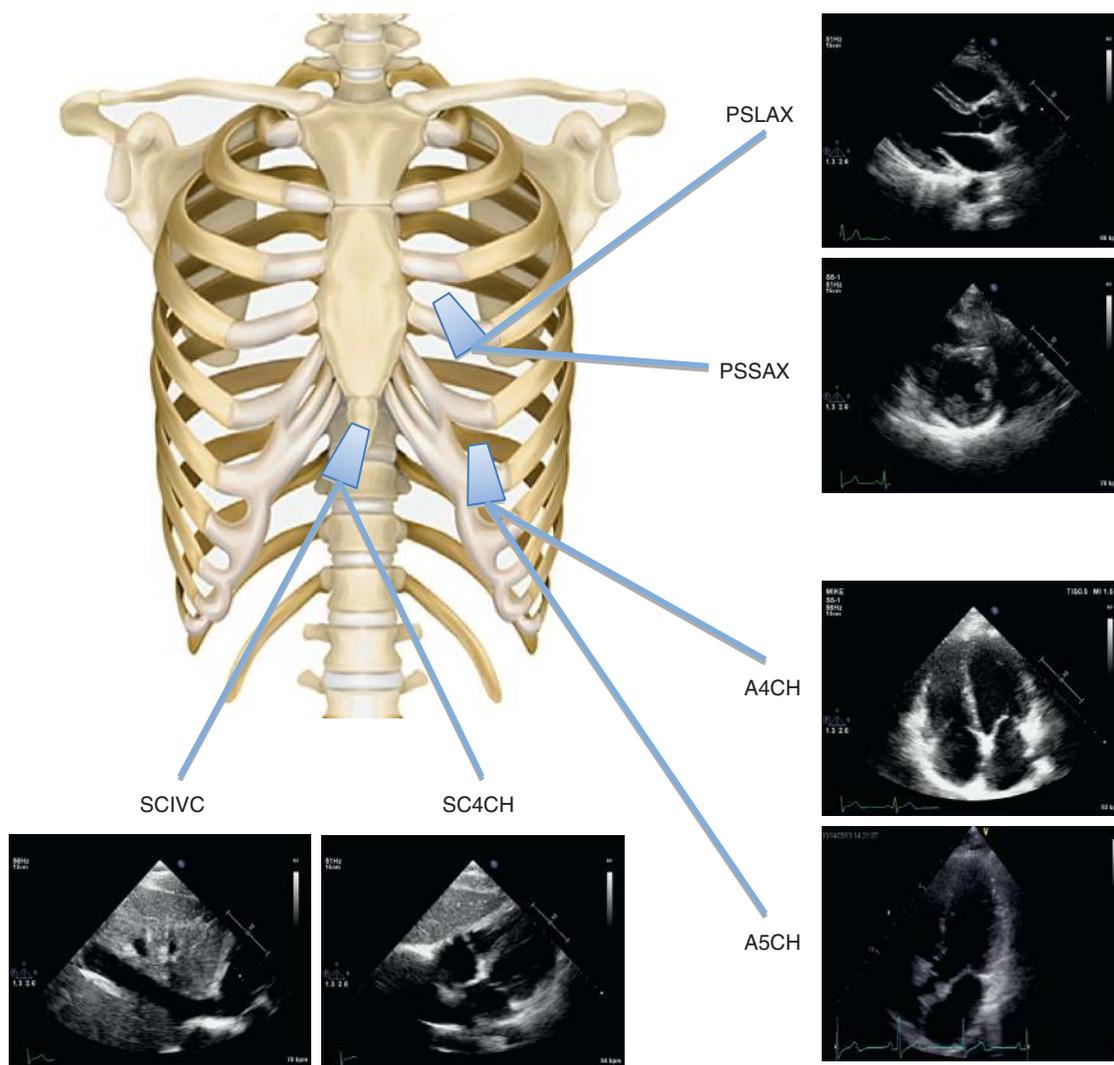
TTE transducer position and imaging windows. Starting with the PS LAX and the probe marker toward 11 o'clock, the clockwise movement and rotation of the transducer will provide a systematic approach to obtaining acoustic windows and imaging views. Rotation of the transducer from the PS LAX view by 90 degrees clockwise will show the PS SAX view. In the PS SAX view, tilting the transducer cephalad or caudad will visualize the short axis of the AV, LV midpapillary, and LV apical. Further rotation of the transducer from 1 o'clock to 3 o'clock and movement to the apical position visualizes the A4CH view. Flattening of the transducer will show the LVOT and A5CH views. Counterclockwise rotation in the apical view will show the A2CH and A3CH views. Maintaining the probe marker in the 3 o'clock position visualizes the SC4CH view in the SC position. The slight rightward angle of the transducer provides the LAX of the IVC. A2CH, Apical two chamber; A3CH, apical three chamber; A4CH, apical four chamber; A5CH, apical five chamber; AV, aortic valve; IVC, inferior vena cava; LAX, long axis; LV, left ventricle; LVOT, left ventricular outflow tract; PS LAX, parasternal long axis; PS SAX, parasternal short axis.
